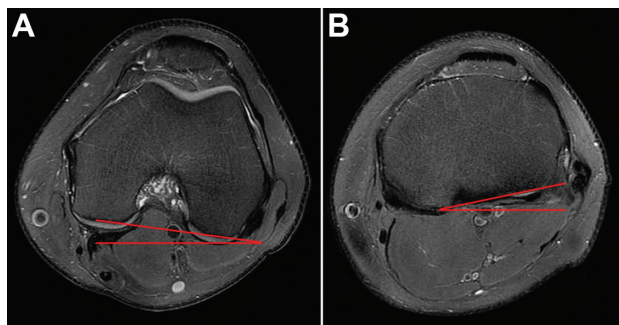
Femorotibial rotation was measured on axial MRI scans. (A) Femoral rotation is the angle between horizontal line and tangential line to the posterior cortex of the femoral condyles. (B) Tibial rotation is the angle between the horizontal line at and tangential line to the most prominent point of the posterior cortex of the tibial condyles. Femorotibial rotation was calculated as the absolute difference between the femoral and tibial rotations, which was given a positive value for internal rotation and a negative value for external rotation.¹⁹ MRI, magnetic resonance imaging.
